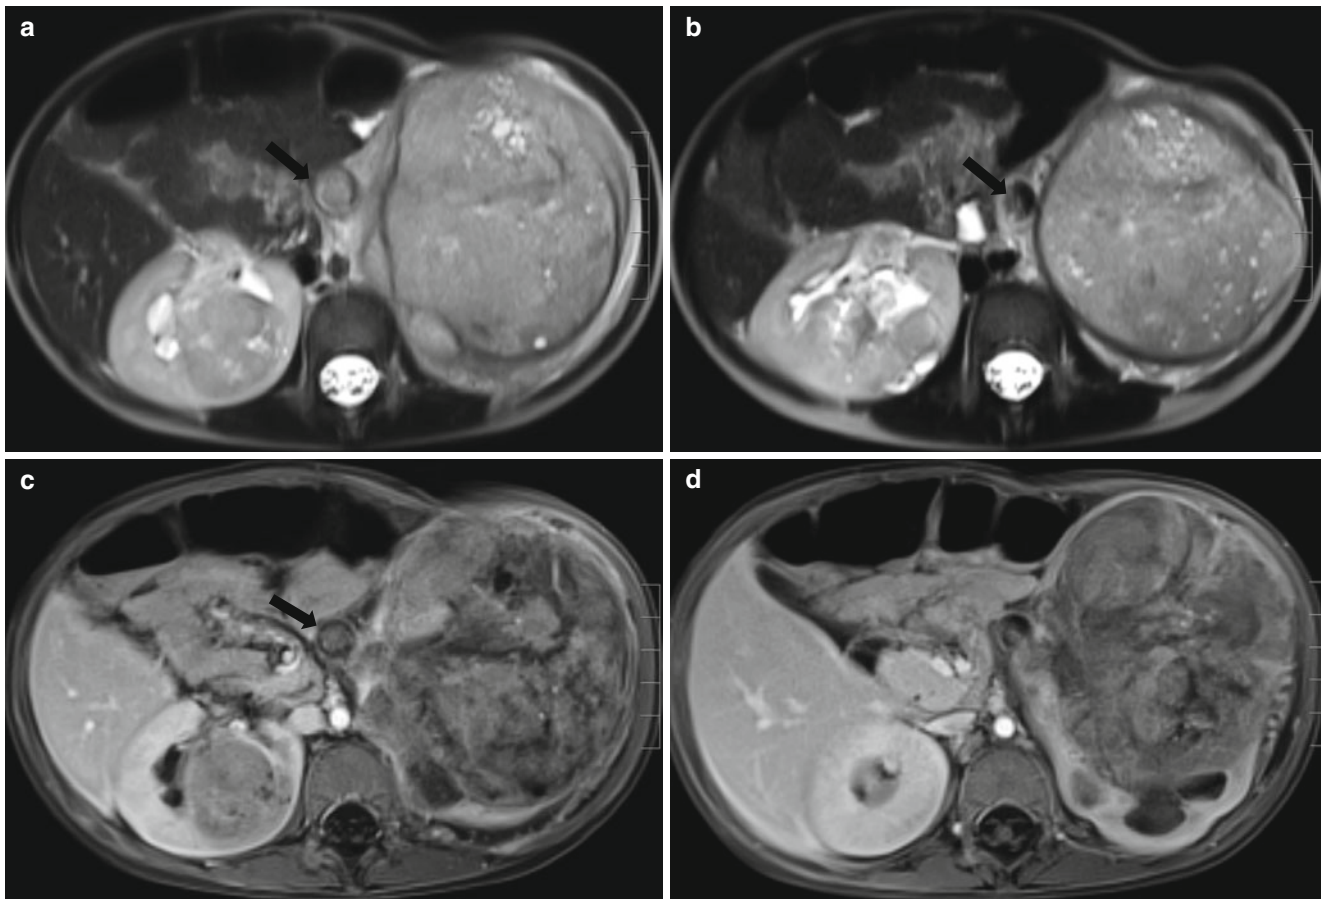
Bilateral Wilms tumor in a 2-year-old boy with Drash syndrome. (a and b) T2-weighted axial MR images demonstrate heterogeneous signal intensity masses in both kidneys. The masses contain internal multiple tiny high-signal intensity lesions within the tumor, which represent necrotic areas. The left renal vein is distended and is
